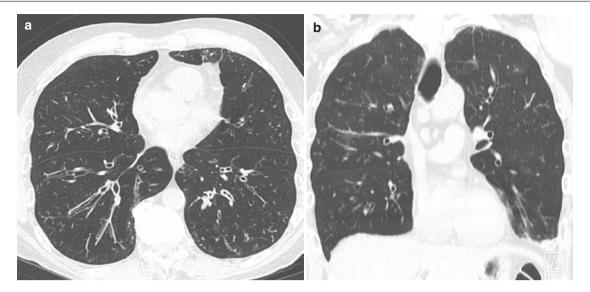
A 61-year-old woman with rheumatoid arthritis and follicular bronchiolitis. (a, b) Axial and CT images show bronchiectasis, bronchial wall thickening, and changes of proliferative bronchiolitis (tree-in-bud opacities, mosaic attenuation, and increased lung volumes)
